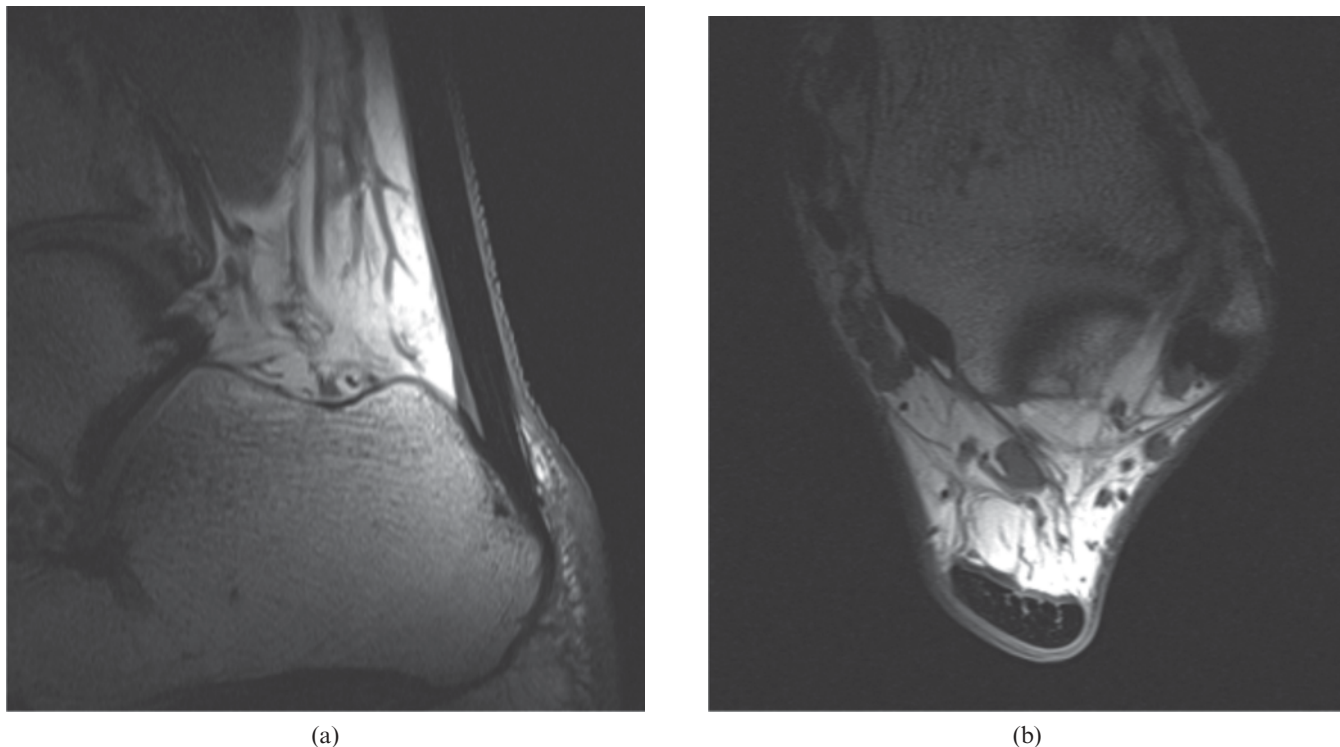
MRI of the normal Achilles tendon. T_1 weighted images of a healthy Achilles tendon, (a) sagittal and (b) axial, just proximal to the calcaneum. The tendon appears with predominantly low signal intensity. Linear and punctuate high signal is seen within the tendon reflecting the complex hierarchical internal structure.
